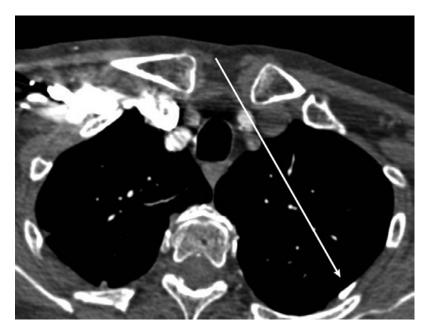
Axial CT demonstrated an extrapleural bone structure in the left hemithorax.
